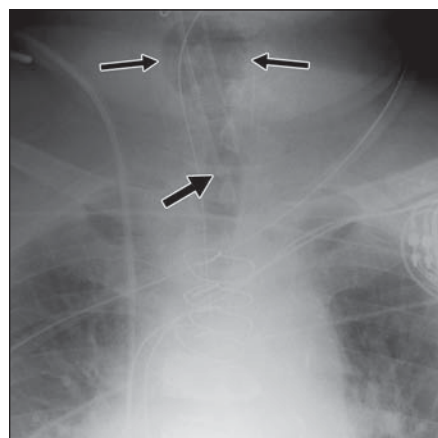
56-year-old woman with misplaced endotracheal tube. Magnified anteroposterior chest radiograph shows that tip of endotracheal tube (thick arrow) is too high, at level of thoracic inlet. Endotracheal tube cuff (thin arrows) is overdistended. This abnormal position may cause vocal cord injury. ←
